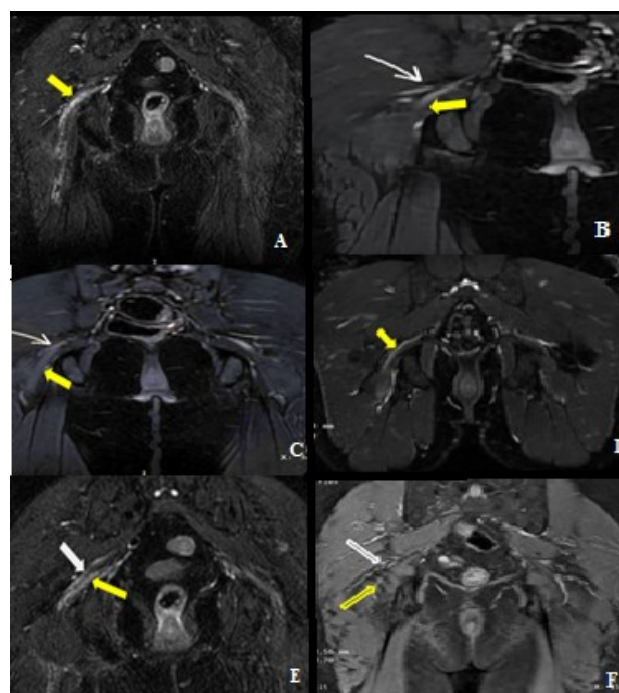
Coronal T2-weighted MRI of the pelvis demonstrating the sciatic nerve–piriformis muscle relationship according to the Beaton and Anson classification. Type I (A): undivided sciatic nerve (yellow arrow) passing inferior to the piriformis muscle. Type II (B): common peroneal nerve (white arrow) passing through the piriformis muscle while the tibial nerve (yellow arrow) passes inferiorly. Type III (C): common peroneal nerve (white arrow) passing superior to the piriformis muscle with the tibial nerve (Yellow arrow) passing inferiorly. Type IV (D): undivided sciatic nerve (yellow arrow) passing through the piriformis muscle. Type V (E): common peroneal nerve (White arrow) passing through the piriformis muscle while the tibial nerve (yellow arrow) passes superiorly. Type VI (F): undivided sciatic nerve (white arrow) passing superior to the piriformis muscle (yellow arrow).
